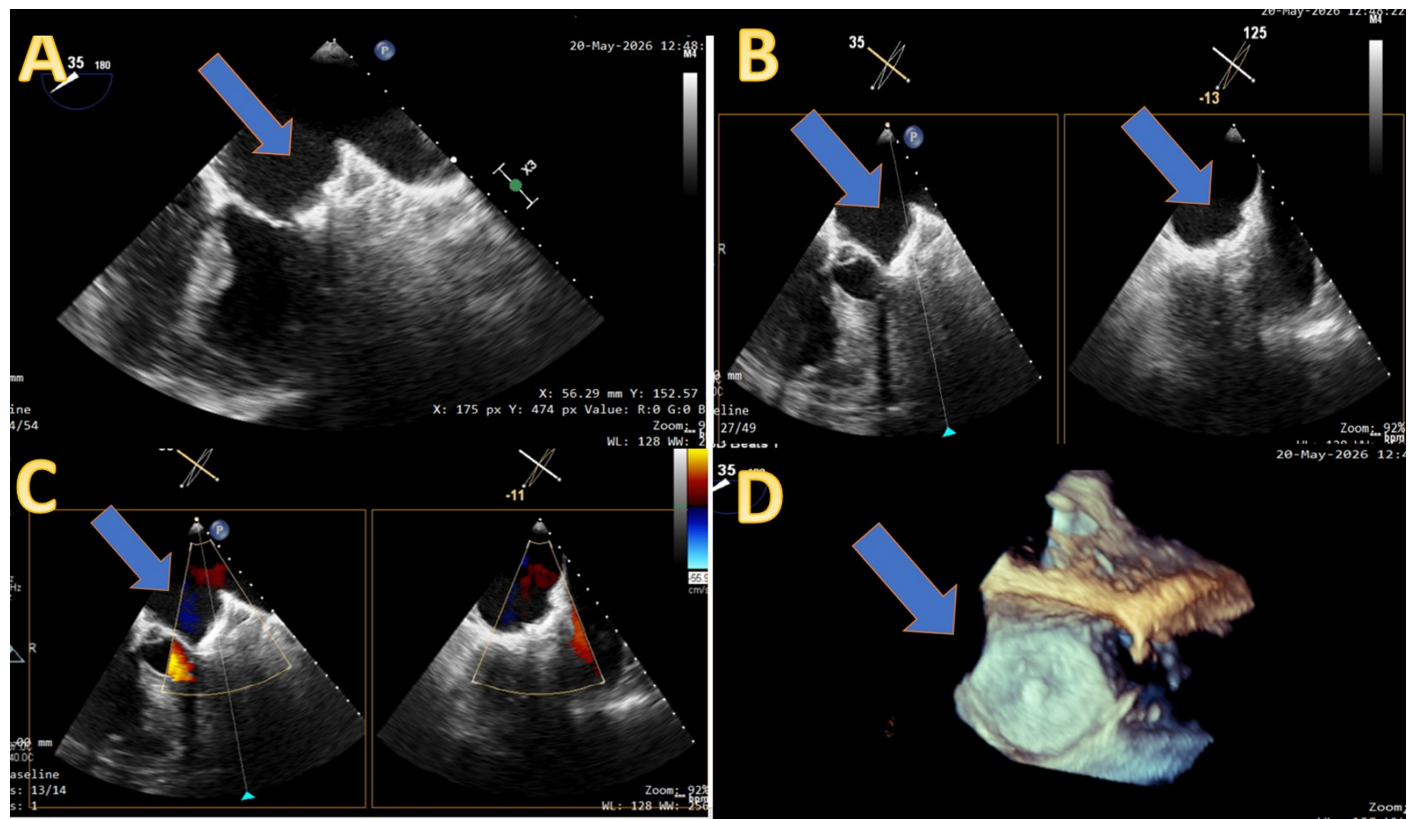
Six-month follow-up TEE. (A) Two-dimensional view of the Amulet device in the appendage, no leak (blue arrow). (B) Biplane imaging at 35° and 125° confirming stable position (blue arrows). (C) Color Doppler showing no peri-device flow (blue arrow). (D) Three-dimensional reconstruction of the device disc (blue arrow). TEE, transesophageal echocardiography.
